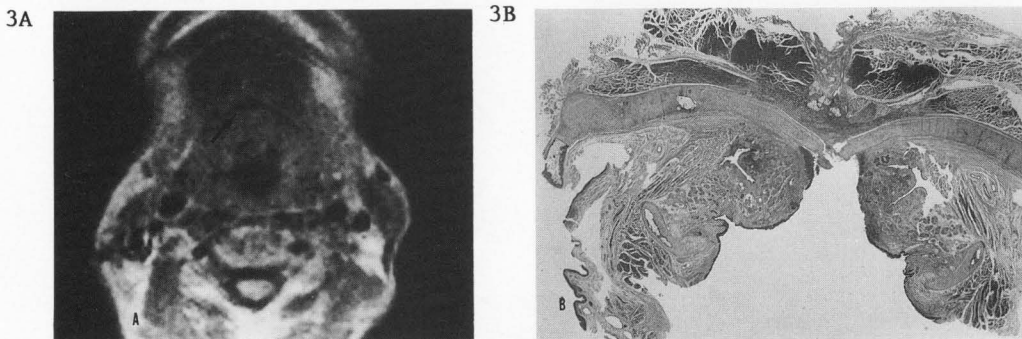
A; Axial MRI at the supraglottic level demonstrates a low signal intensity mass in the preepiglottic space (arrow).
